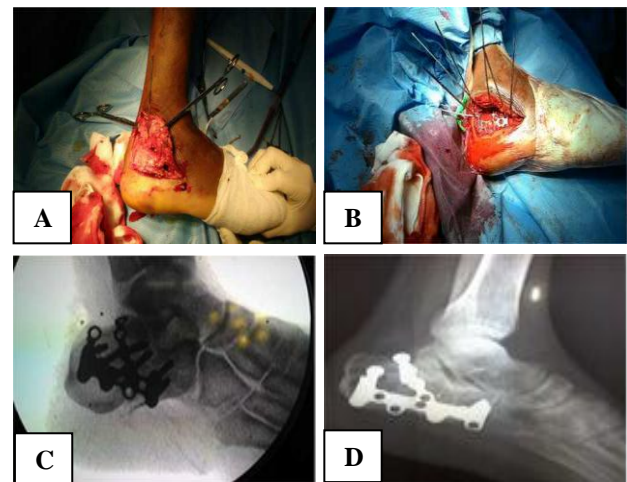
(A-D): A=Lateral approach to the calcaneum, B=Intraoperative picture showing plate fixation, C=Intraoperative fluoroscopic picture, D=Postoperative radiograph at 24 weeks follow-up.
